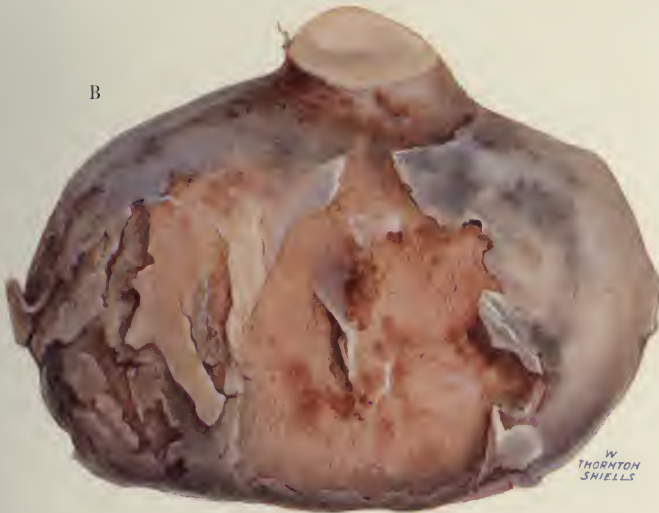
Showing (A) sessile subserous and (B) pedunculated subserous myomata. The right appendages have been removed, the left were not taken away. The patient had been treated by X-rays; twelve sittings produced no abatement of menorrhagia, and the tumour increased in size. The right ovary was atrophic, the left one normal in size and appearance.
